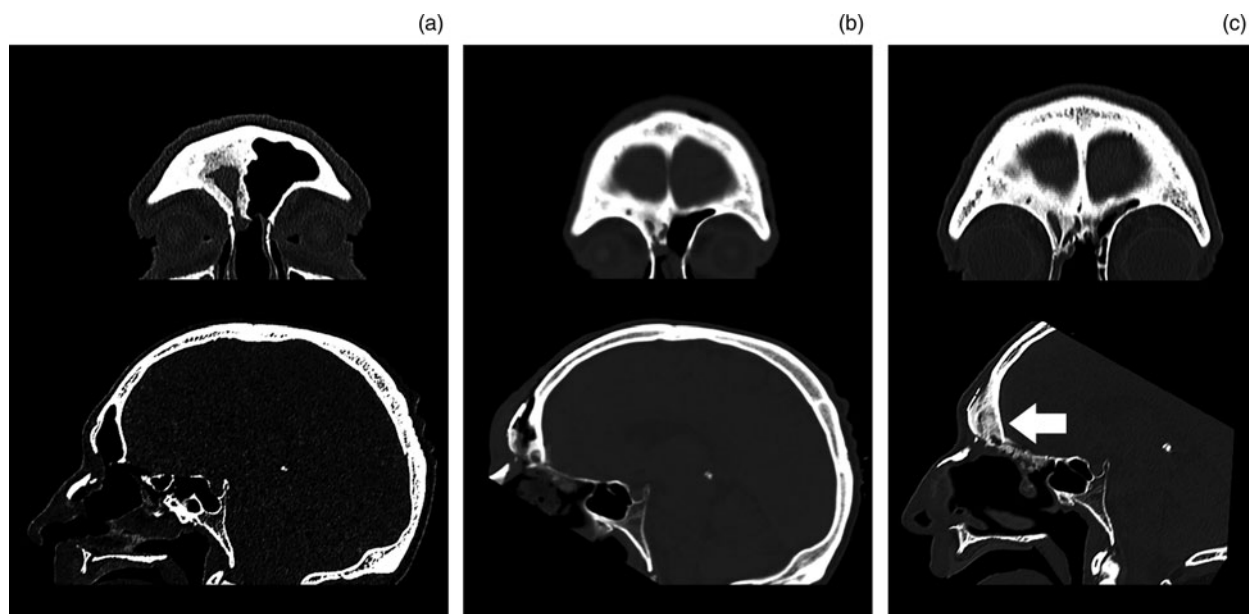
Patient 2 – non-contrast, coronal and sagittal computed tomography bone window images of the frontal sinus: (a) pre-operatively, (b) day 1 post-operatively and (c) 6 months post-operatively, demonstrating osseous integration of the beta-tricalcium phosphate putty (large arrow).
